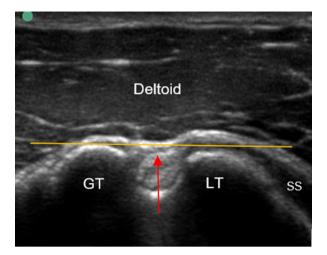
Ultrasound imaging of the bicipital groove for humeral retroversion measurement. The humerus is rotated until the superficial aspects of the bicipital groove (*yellow line*) are horizontal, and then the forearm inclination angle is measured representing humeral retroversion. *GT*, greater tuberosity; *LT*, lesser tuberosity; *SS*, subscapularis.
